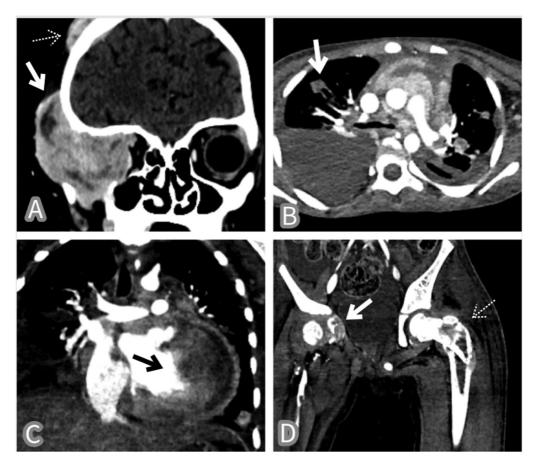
Contrast-enhanced computed tomography (CECT) images showing lesions involving orbit (A, solid arrow), calvaria (A, dotted arrow), bilateral lungs (B, white arrow), endo-myocardium (C, black arrow), pubic ramus (D, solid arrow), and femur (D, dotted arrow). Images (B) and (C) show extensive endomyocardial involvement.
